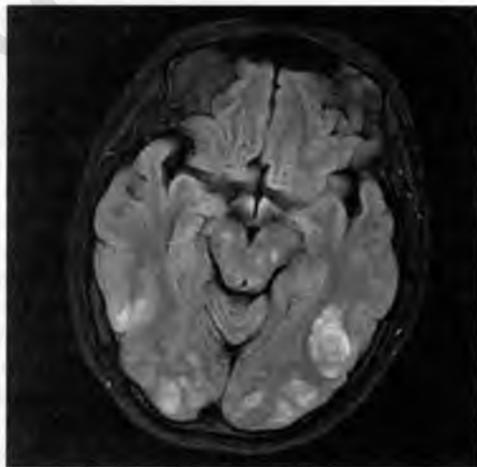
MRI findings in PRES
